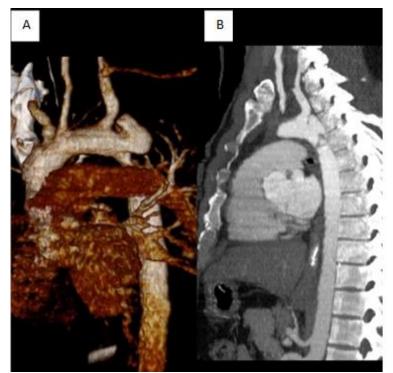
1A, 1B: VR and MIP reconstruction of preoperative CT angiography depicting pseudoaneurysm.
